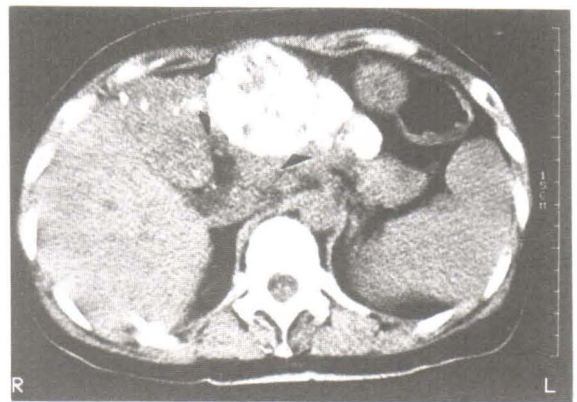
Same case as in Figure 14, follow-up 1 month post TOCE. Lipiodol CT scan shows complete opacification of HCC by lipiodol (arrow) with significant decrease in tumor size compared to last exam (compared to Figure 14).
